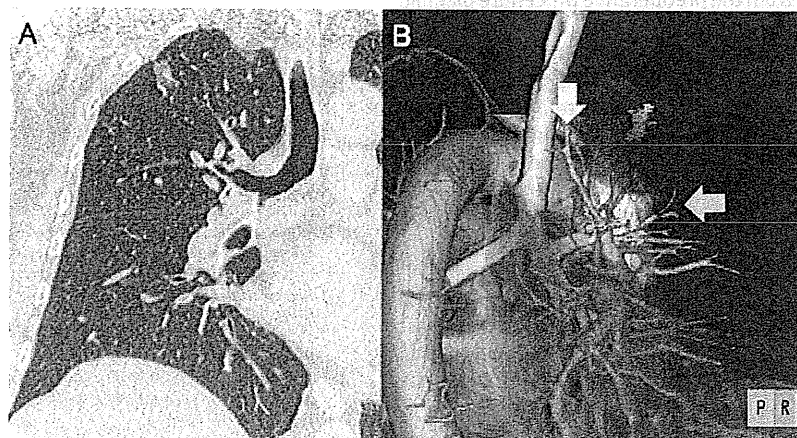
A 68-year-old female. (A) A non-solid lung cancer in the right S1 segment is seen on coronal CT; the maximal tumor diameter is 1.4 cm. (B) 3D-CTA with the virtual safety margin. The relevant intersegmental veins are V1b, between S1 and S3 (yellow arrow), and V2a, between S1 and S2 (white arrow). Because both intersegmental veins are running outside of the virtual safety margin, S1 segmentectomy is able to be performed. (For interpretation of the references to color in this figure legend, the reader is referred to the web version of the article.)
